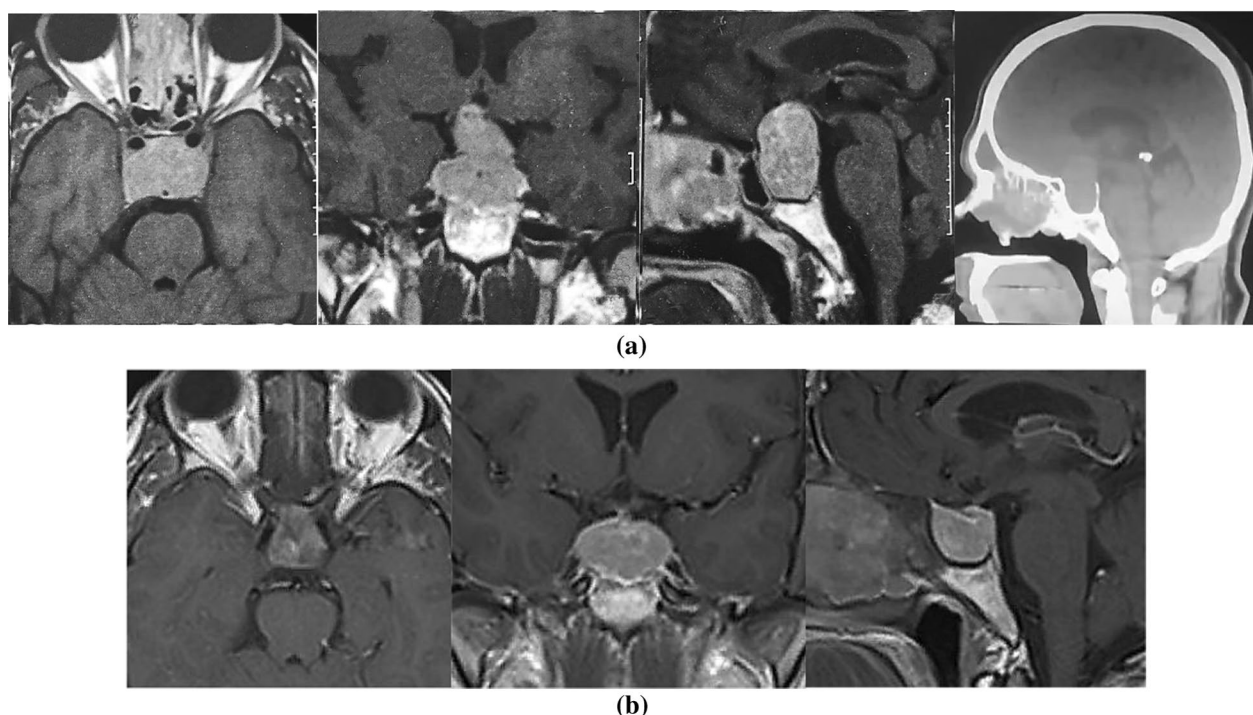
a 49 year old male patient with giant pituitary adenoma and conical type sphenoid sinus was operated upon through extended pterional approach. b One month Postoperative MRI post-contrast showing decompression of the optic apparatus and reduction of the tumor mass
